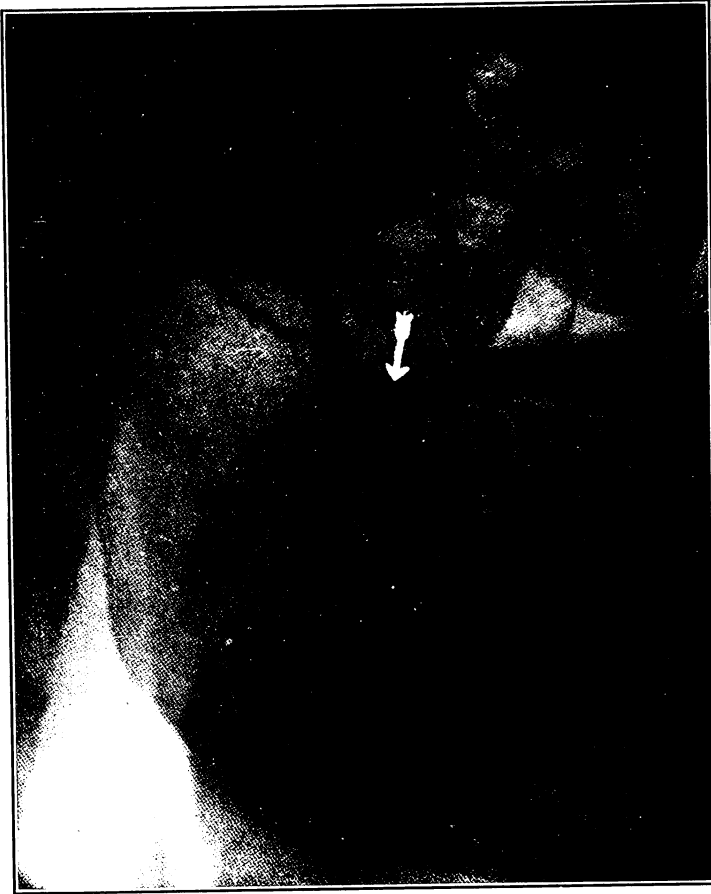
Radiograph made from the pose similar to figure 101. The arrow points to an impacted upper third molar. The lack of detail in this, and all radiographs made from a similar pose, is due to a super-imposition of shadows—the shadow of one side of the jaw is mingled with the shadow of the other. (Radiograph by A. M. Cole and Raper.)
